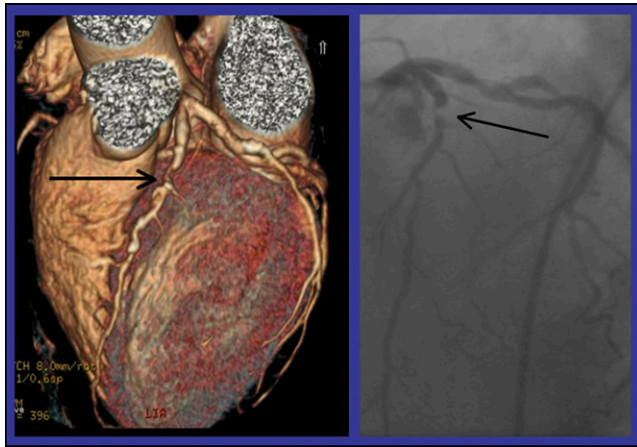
The addition of PET improved the diagnostic performance of CT angiography over CT angiography alone. Left, a left anterior descending lesion on CT angiography with PET; right, the same lesion on conventional invasive angiography.
